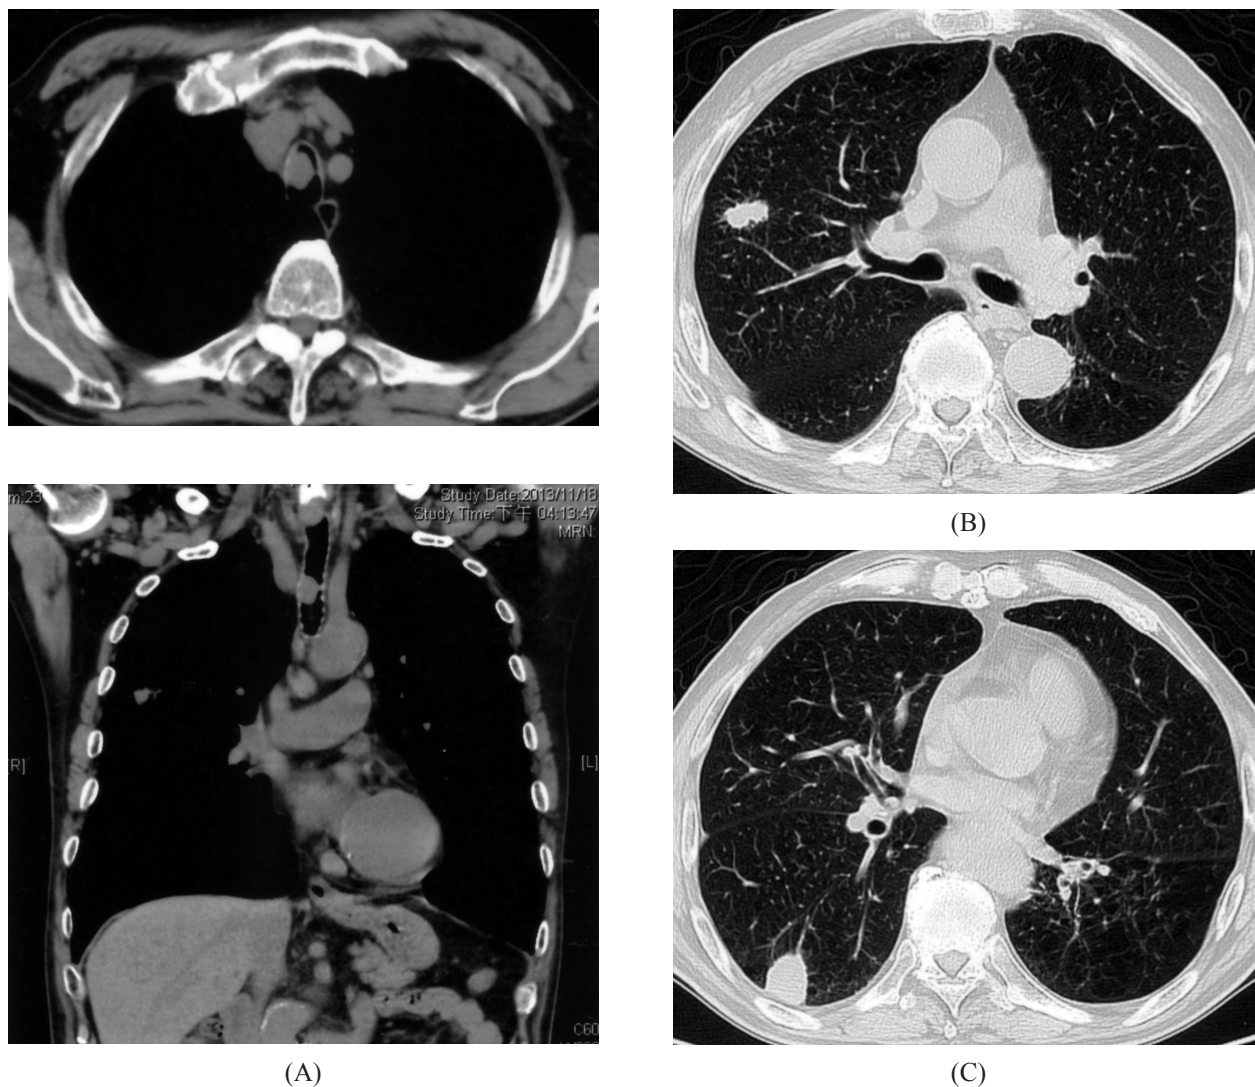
Chest computed tomography reveals the following. A) a 1.9 cm soft tissue density in the right tracheal wall. B) a spiculated soft tissue lesion in the right upper lobe (1.9 cm). C) a spiculated soft tissue lesion in the right lower lobe (2.3 cm).
